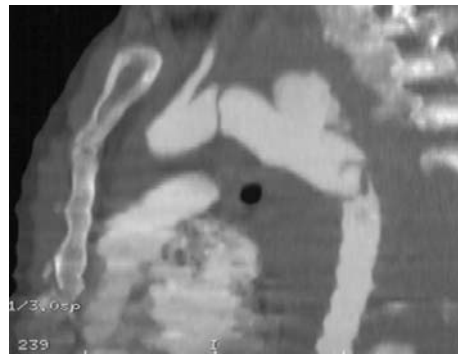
Aortic rupture on the computed tomography scan
